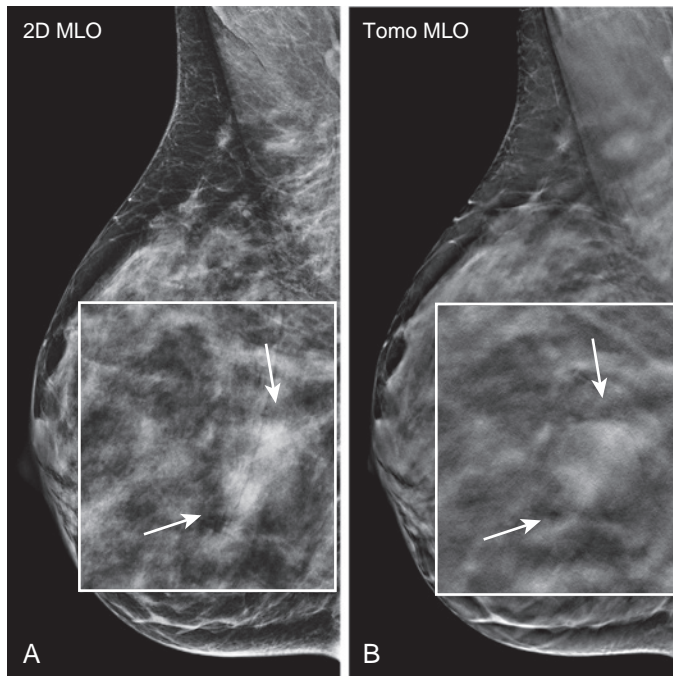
Skin fold obvious on tomosynthesis and not requiring a technical repeat. Screening mammogram in a 42-year-old woman reveals heterogeneous dense breast tissue. (A) A skin fold and asymmetry are seen in the right posterior breast in the MLO view (arrows). (B) Because the exam was performed in combination mode, tomosynthesis revealed the skin fold on the first slice and a well-circumscribed mass located on a medial slice (arrows). Technical repeat mammography views were unnecessary. Targeted ultrasound (not shown) revealed a simple cyst.
